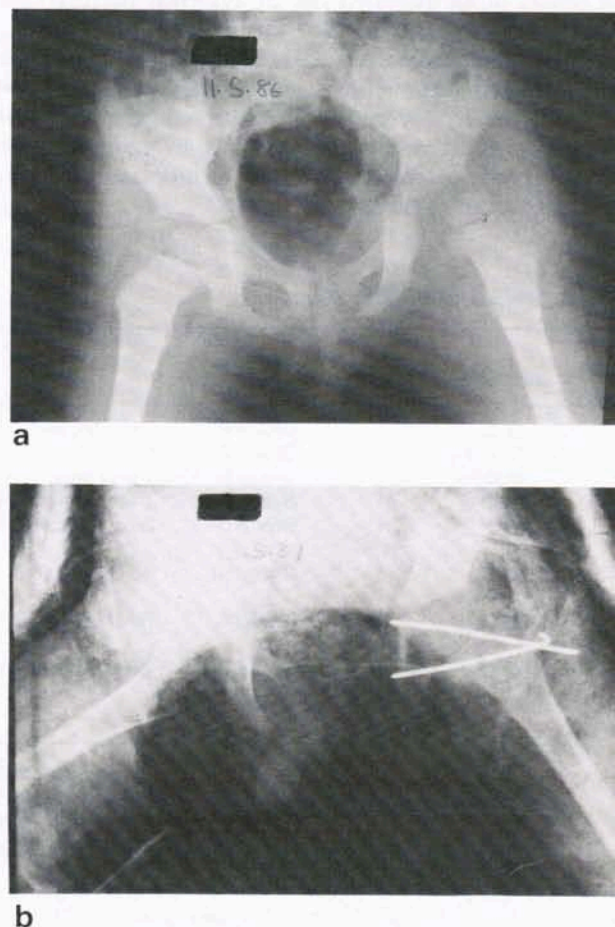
This 3-year-old patient was treated for posterior dislocation of the right hip by heavy traction. *a*, Radiograph 3 weeks later shows increased medial joint space. *b*, The hip was reduced through a posterolateral approach and stabilized with transarticular Kirschner wires and a hip spica cast.
